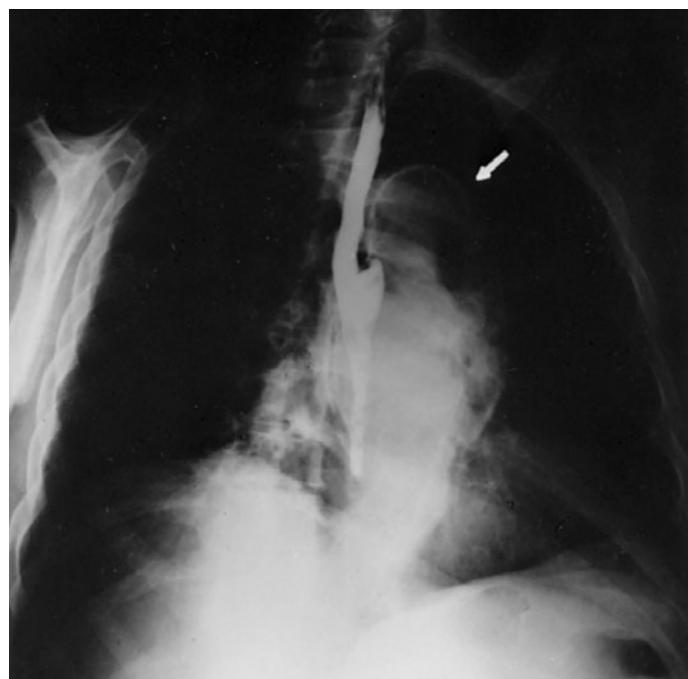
Chest radiograph, after barium swallow, of a 56-year-old man with a history of incompletely treated syphilis. Marked calcification can be seen within the aneurysm of the ascending aorta (arrow). (Courtesy BW Gayler.)
